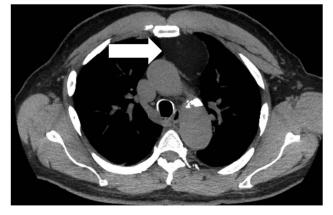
Thoracic computed tomography, transverse view. The arrow identifies a well-encapsulated large $7.5 \times 5 \times 6$ cm lipomatous anterosuperior mediastinal mass adjacent to the left phrenic nerve.
